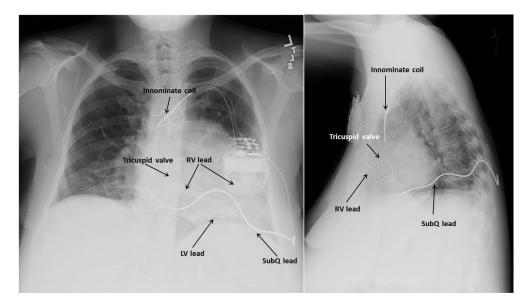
Figure Left: Posteroanterior radiograph view of cardiac resynchronization therapy defibrillator (CRT-D) system. Right: Lateral radiograph view of CRT-D system. Right ventricle (RV), left ventricle (LV) and subcutaneous (SubQ) leads are shown with *arrows*. Note the lower location of the device position.
